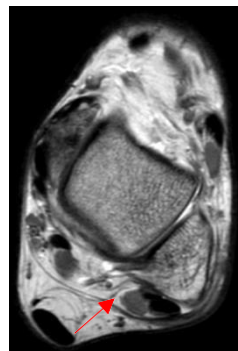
Axial MRI ankle. Red arrow show peri-tendon fluid collection
